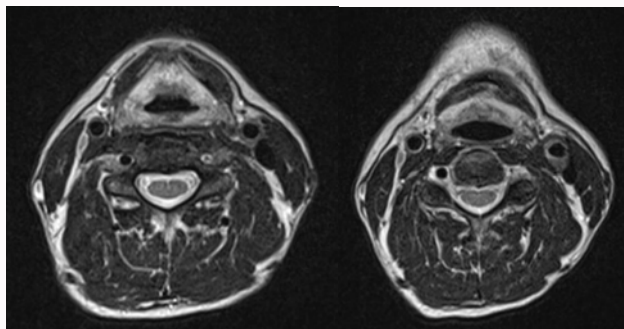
MRI showing thickening of the distal left common carotid artery and carotid bifurcation.
